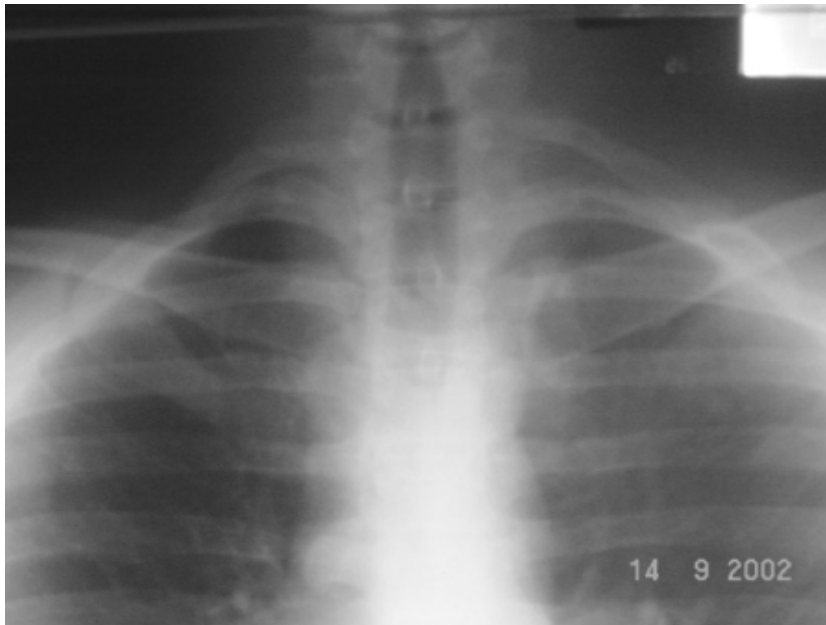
Chest x-ray showing a cervical rib
